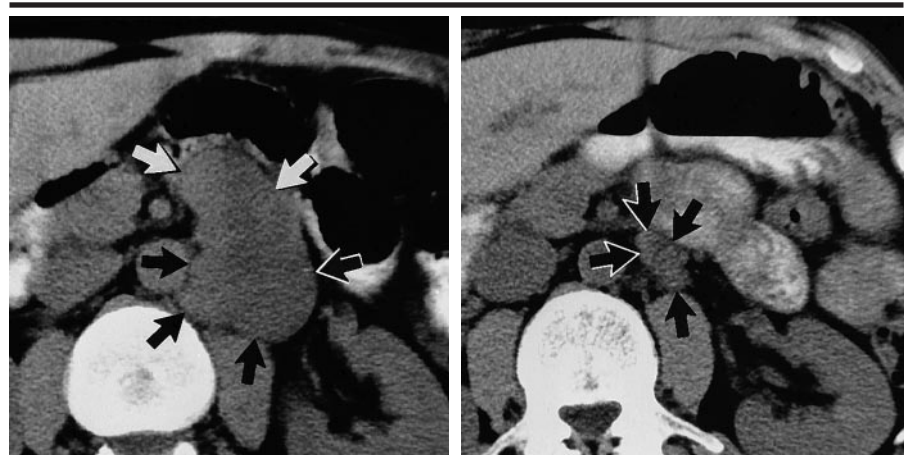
CT images show a left paraaortic mass (arrows) with a maximum transverse diameter of (a) 50 mm before chemotherapy and (b) 15 mm after chemotherapy. The residual mass contained fibrosis and some remnants of mature teratoma.
